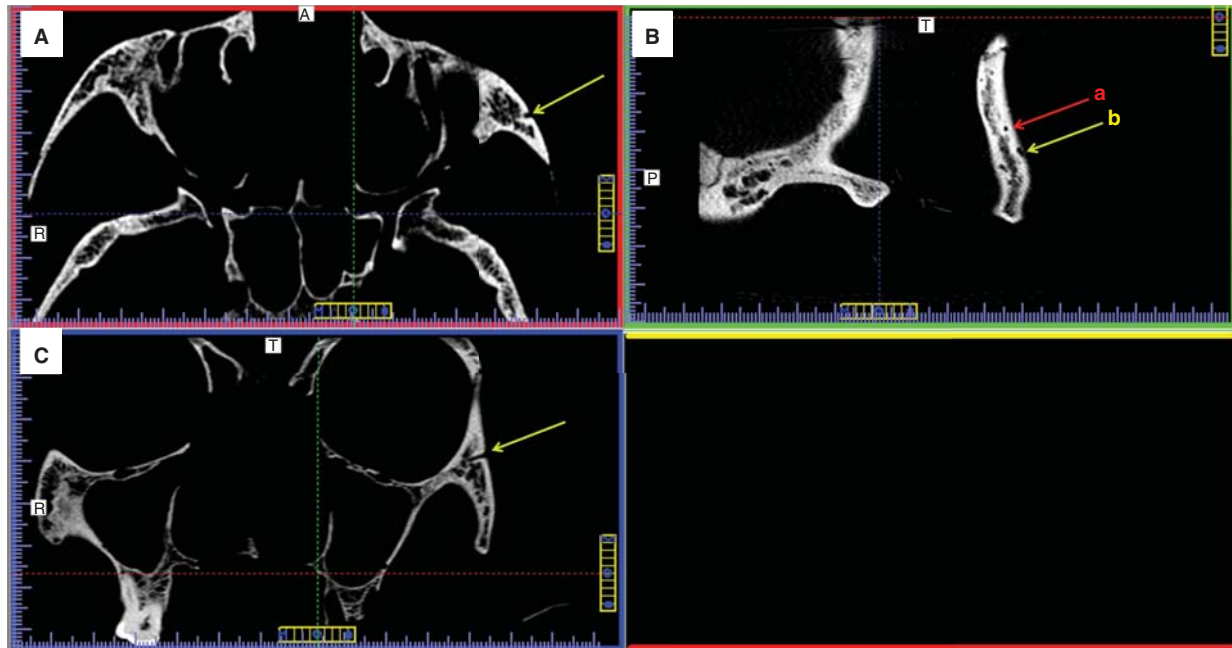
Representative CBCT images of reformatted axial (A), sagittal (B) and coronal (C) slices. The arrows indicate the ZFFs. In this example, two foramina are presented, with diameters of 0.16 mm (a) and 0.8 mm (b).
